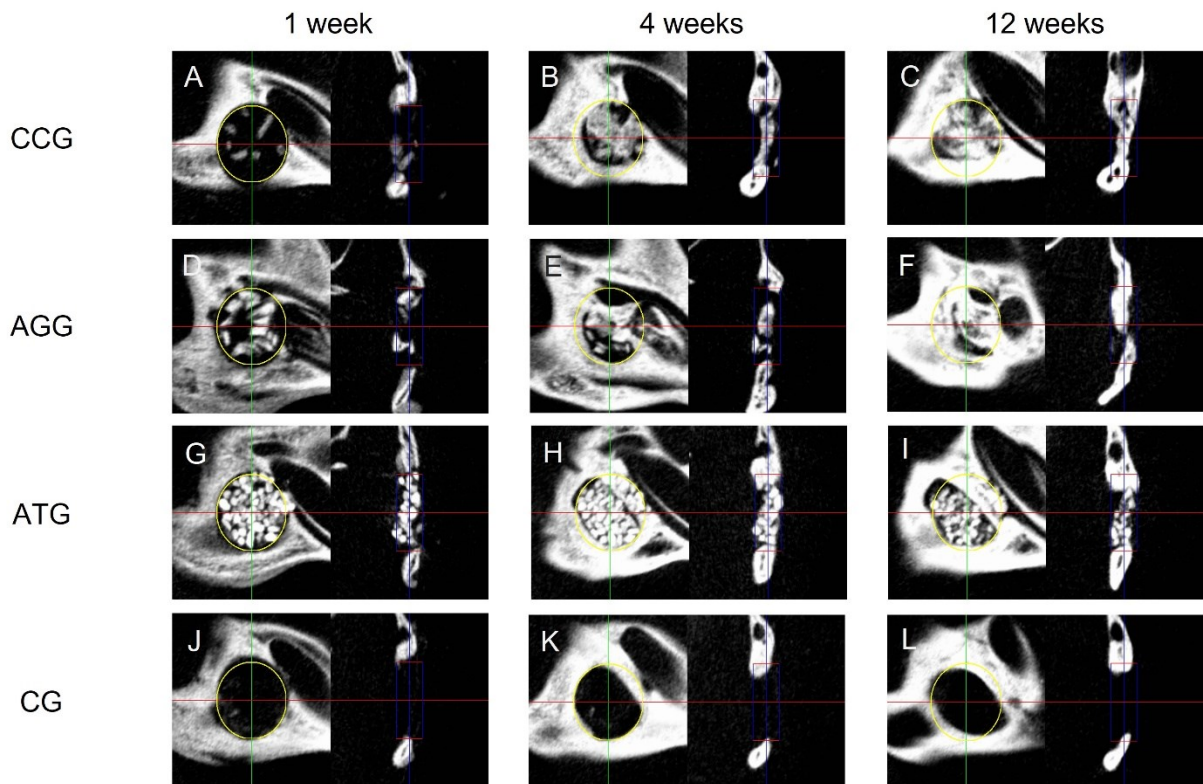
Representative sagittal (left) and coronal (right) computed tomography images
